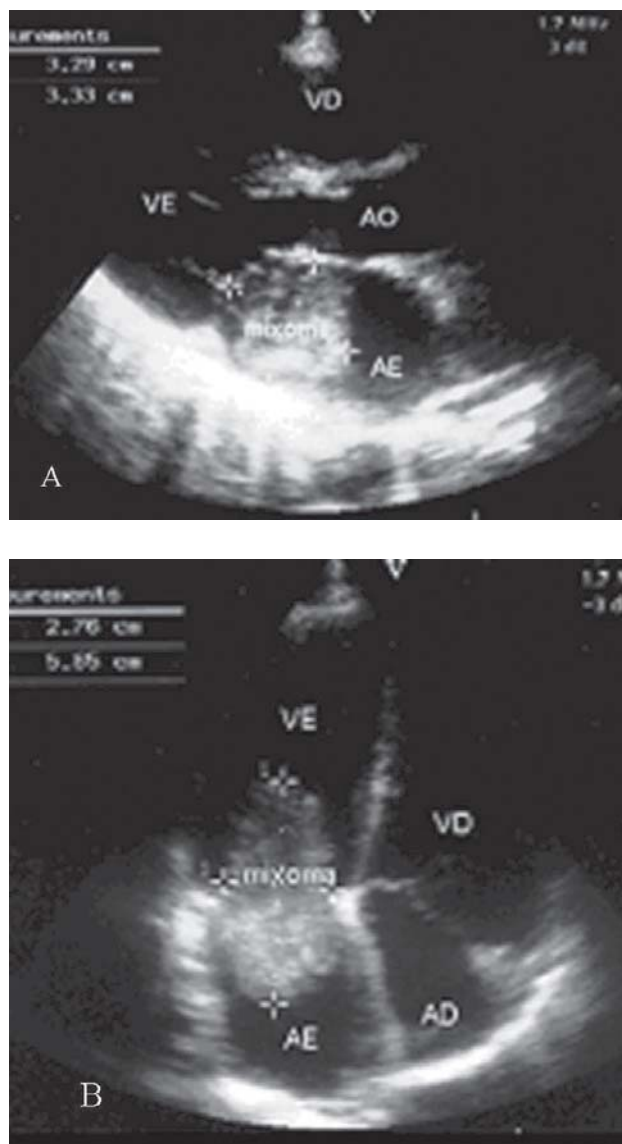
Transthoracic echocardiogram. A - Preoperative. B - Atrial tumor prolapse through the mitral valve toward the left ventricle during ventricular diastole
